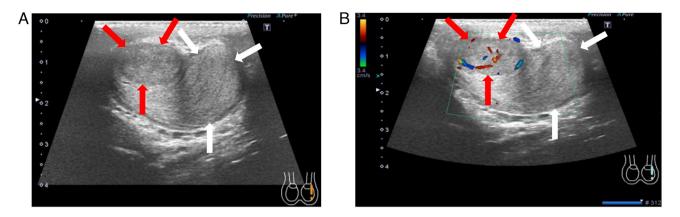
Preoperative ultrasonography of the left testis. (A) Ultrasonographic image shows an isoechoic mass with clear margins in the cranial part and an isoechoic mass with clear margins in the caudal part. (B) Color Doppler ultrasonographic image shows abundant blood flow in the cranial and poor blood flow in the caudal mass. The red and white arrows indicate the cranial mass and caudal mass, respectively.
